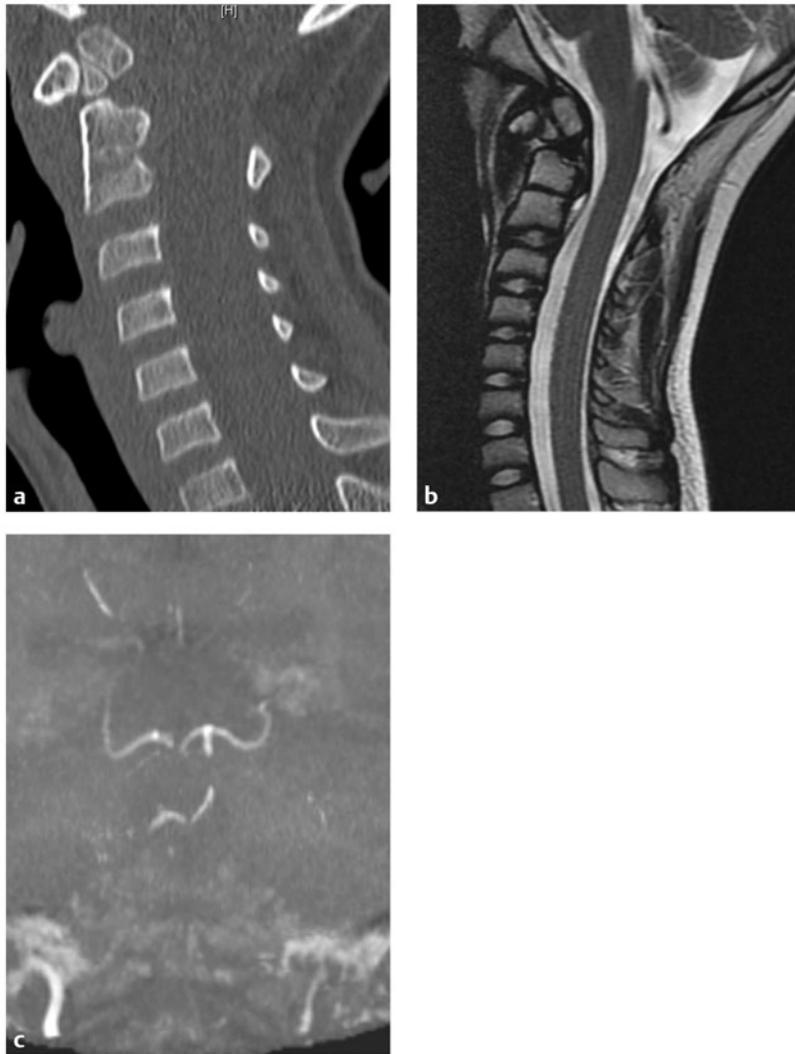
Os odontoideum. Preoperative (a) sagittal computed tomographic and (b) sagittal magnetic resonance (MR) imaging of the same patient as in ▶ Fig. 61.8 clearly shows a well-corticated ossicle in the region of the dens in discontinuity with the remainder of the axis. (c) Preoperative MR angiogram from this patient demonstrating severe vertebral artery insufficiency from kinking of the vertebral arteries due to C1–2 instability.
